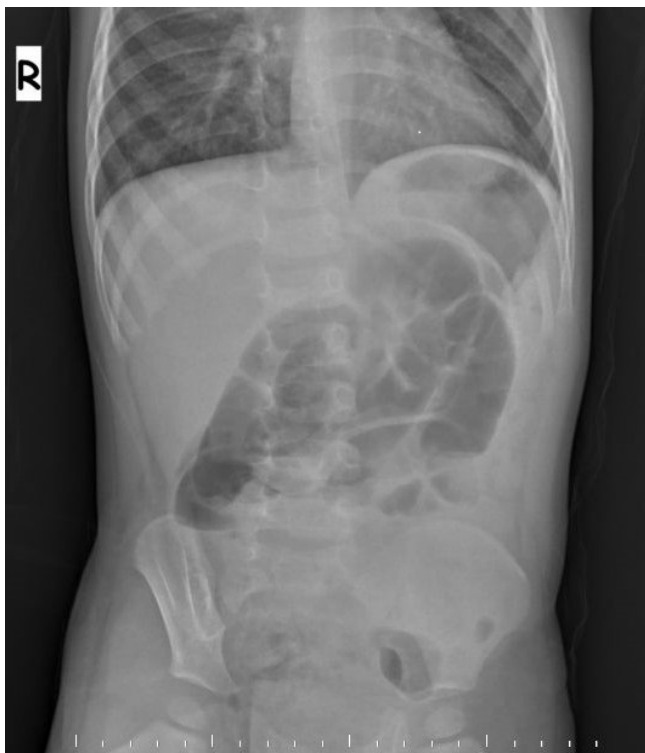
Abdominal radiograph shows air-fluid levels in projection of small bowel loops.
